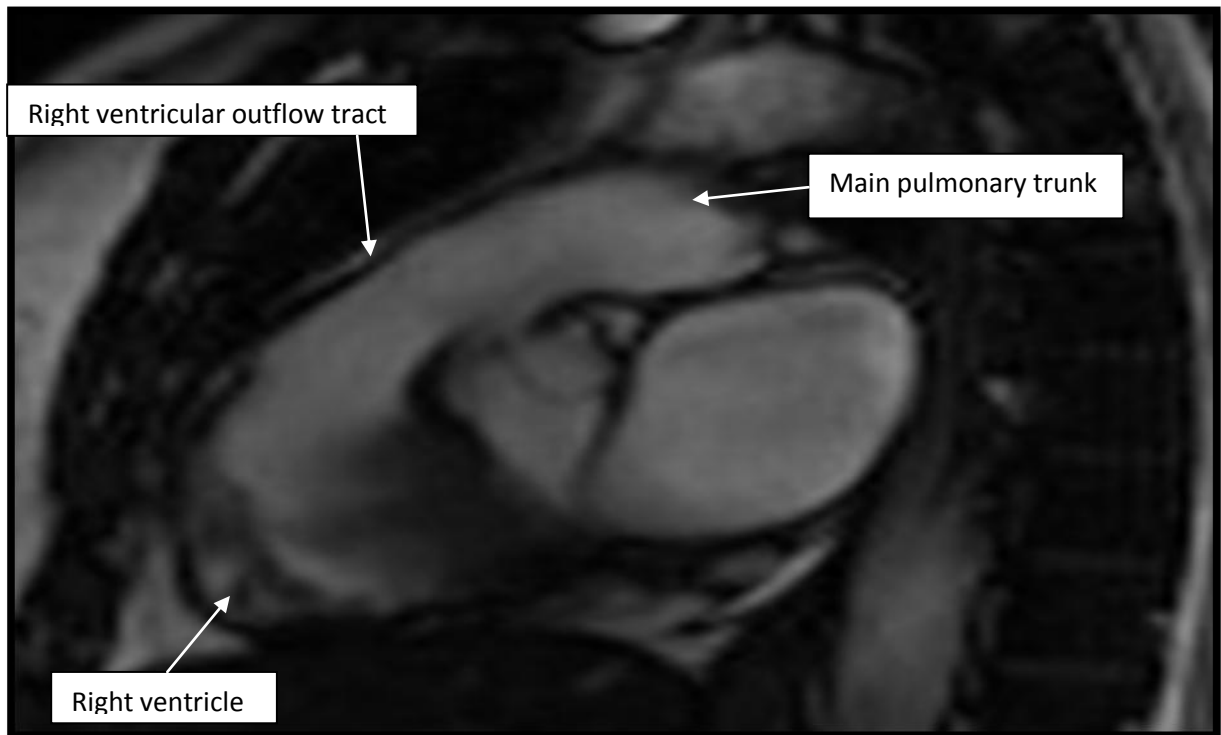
MRI CINE right ventricular outflow tract at systole
